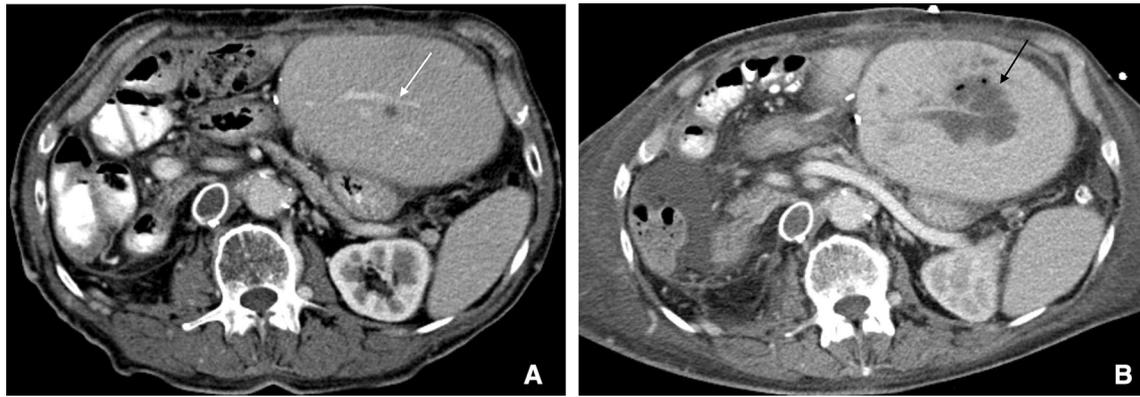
Hepatic abscess after TACE. 70-year-old male patient with multi-focal recurrence of an intrahepatic cholangiocellular carcinoma after right hemihepatectomy. On the pre-interventional CT scan (a), there were several small ICC nodules (white arrow) spread throughout the liver remnant. 10 days after the first TACE, the patient returned
